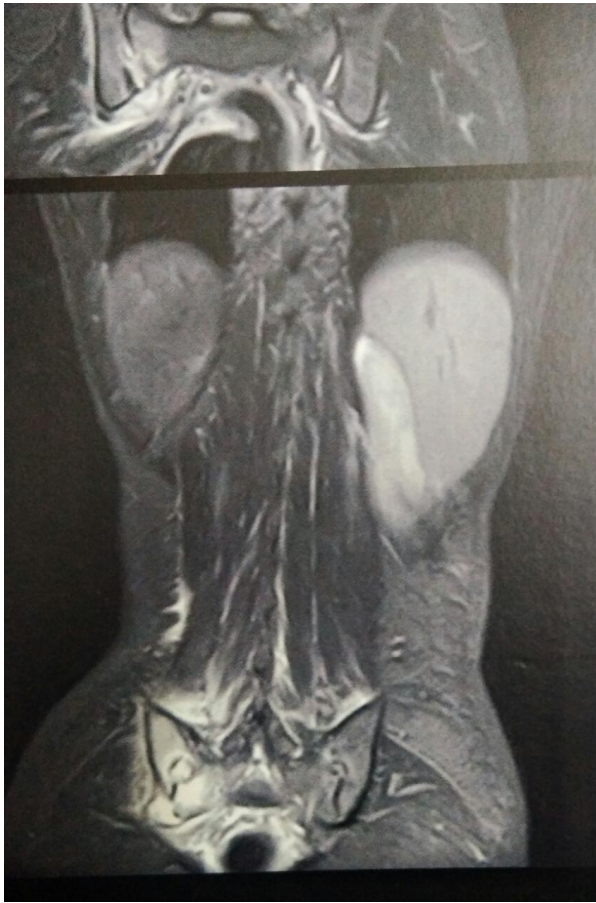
MRI picture of sacroiliitis
